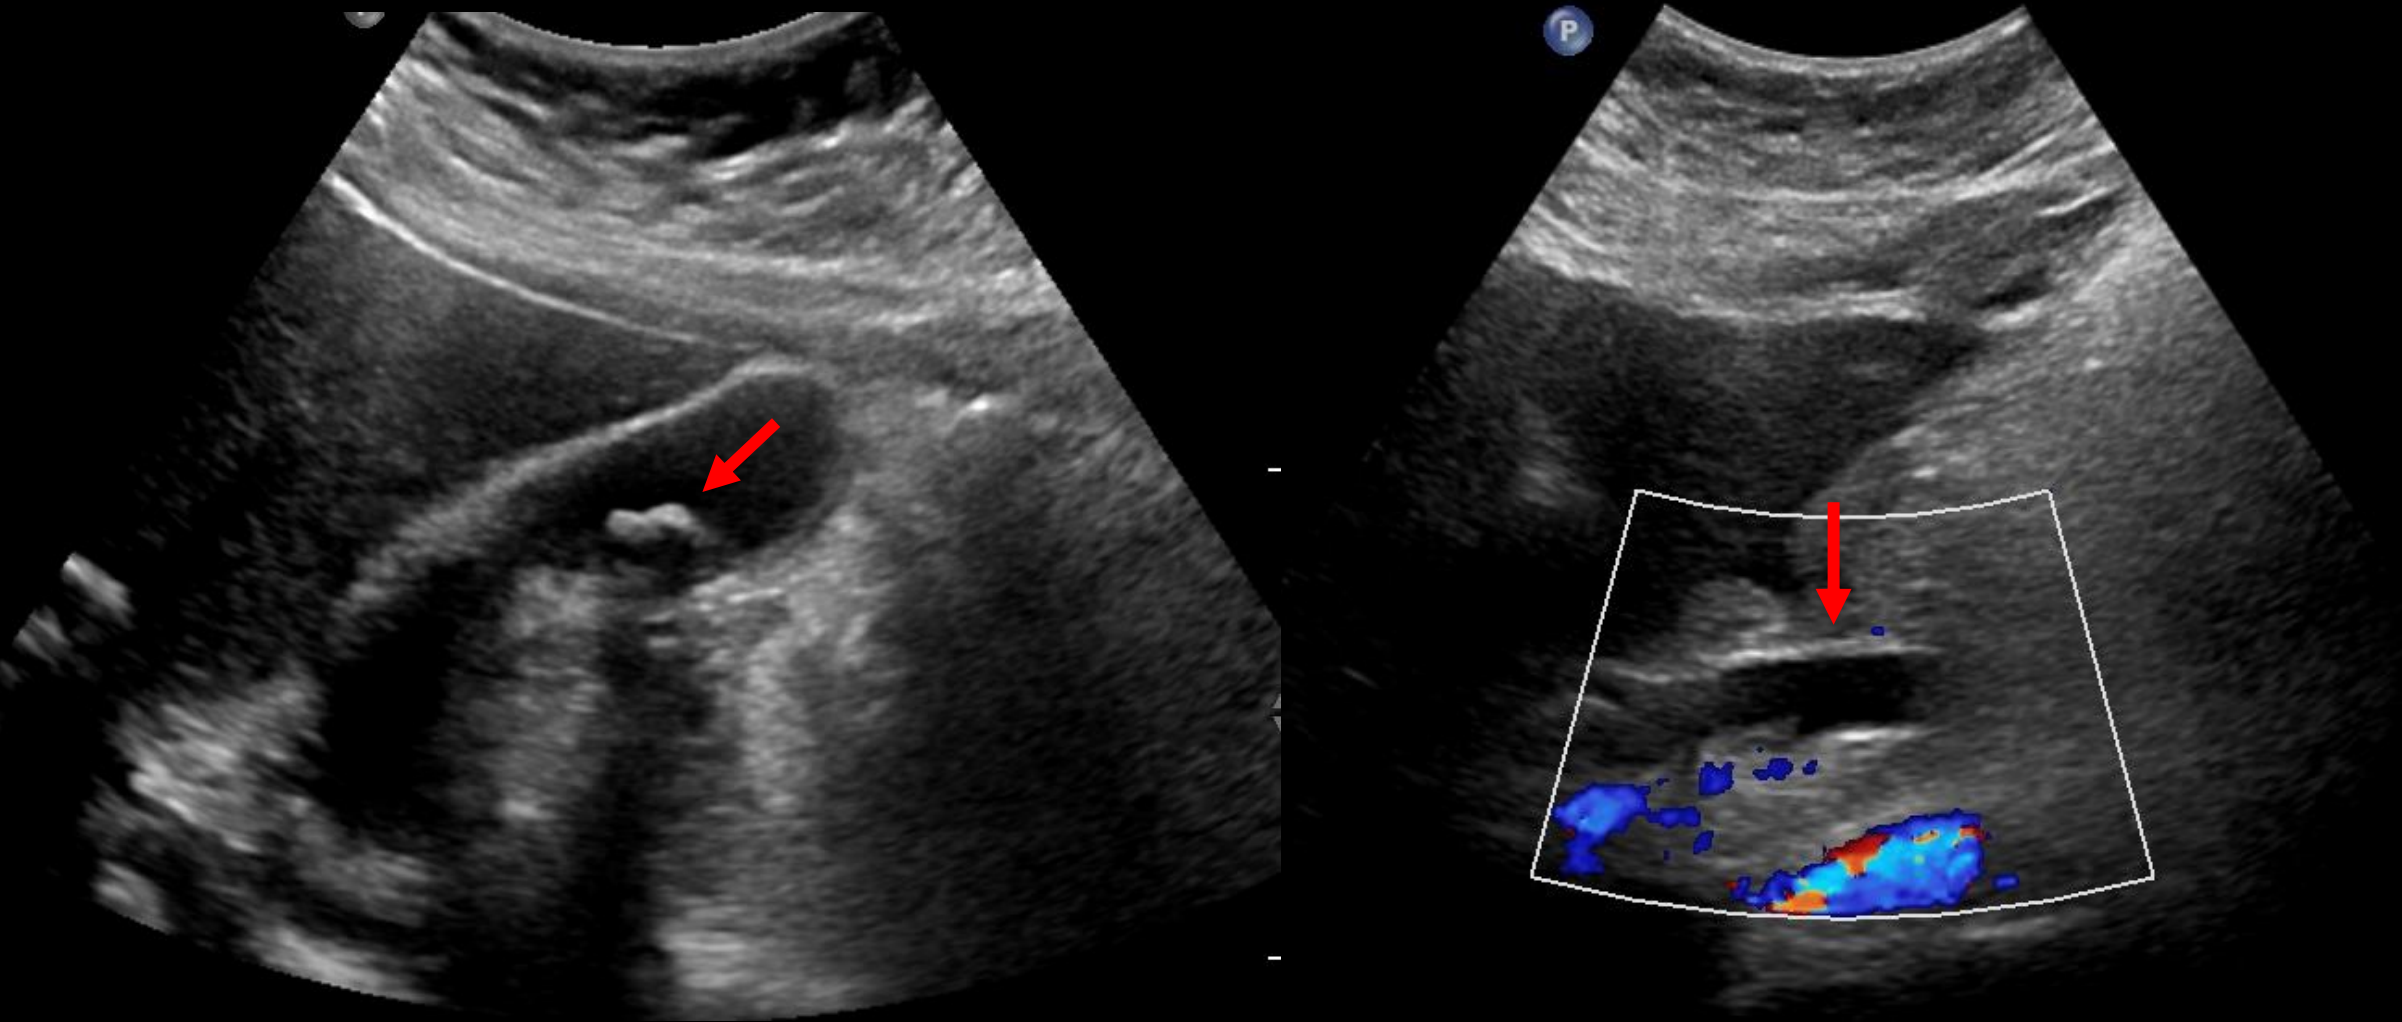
A. Ultrasound examination of the gallbladder demonstrates two echogenic, shadowing calculi within the dependent portions of the gallbladder. B. On the same examination, there is dilation of the CBD up to 1.0 cm.
